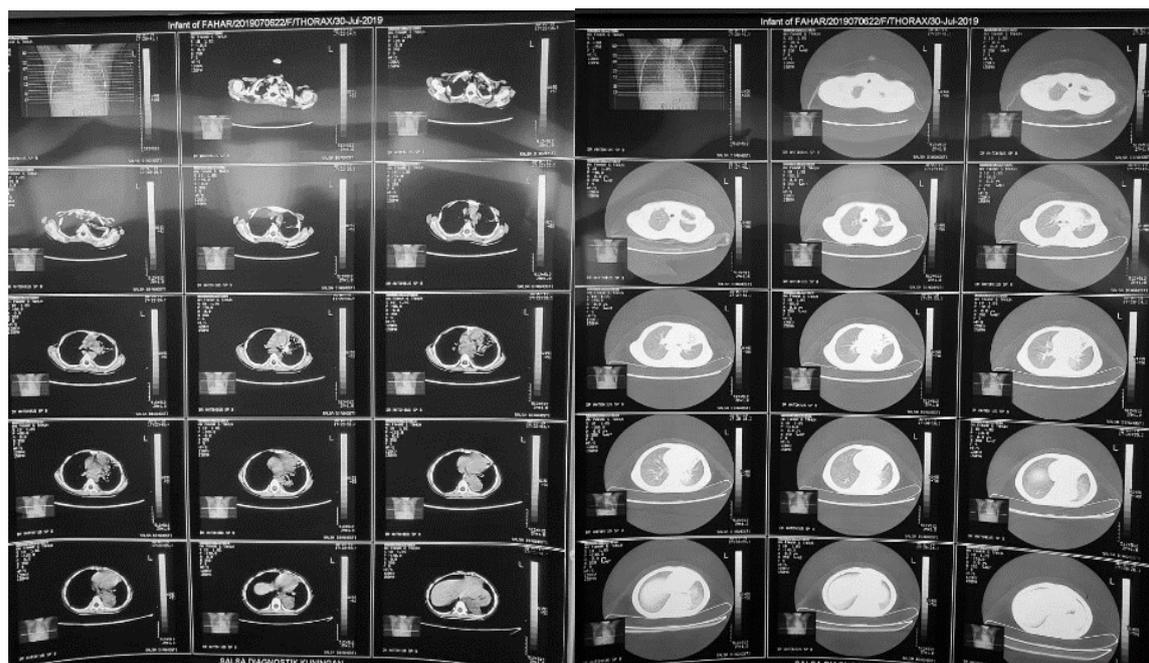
Computed Tomography (CT scan) of the thorax.
